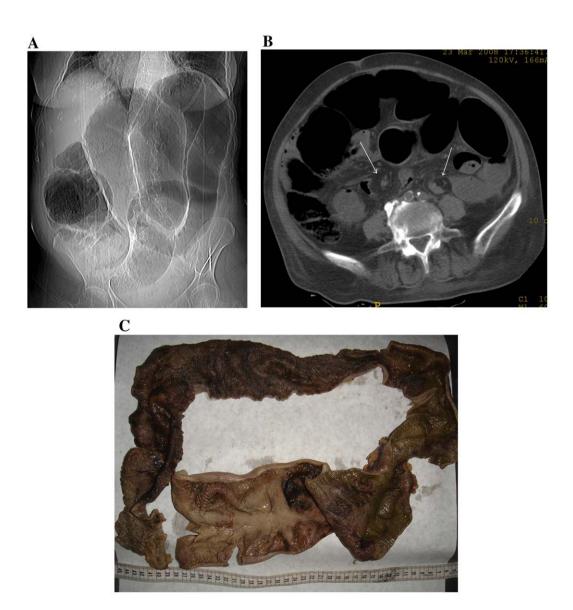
A and B. Computed tomography suggestive of double sigmoid and transverse colon volvulus in a patient with ulcerative colitis (arrows in B are showing the two wheels of bowel rotation in two areas, we decided to call this the 'motorcycle sign'). C. Large bowel removed on emergency in a patient with ulcerative colitis and double sigmoid and transverse colon volvulus.
